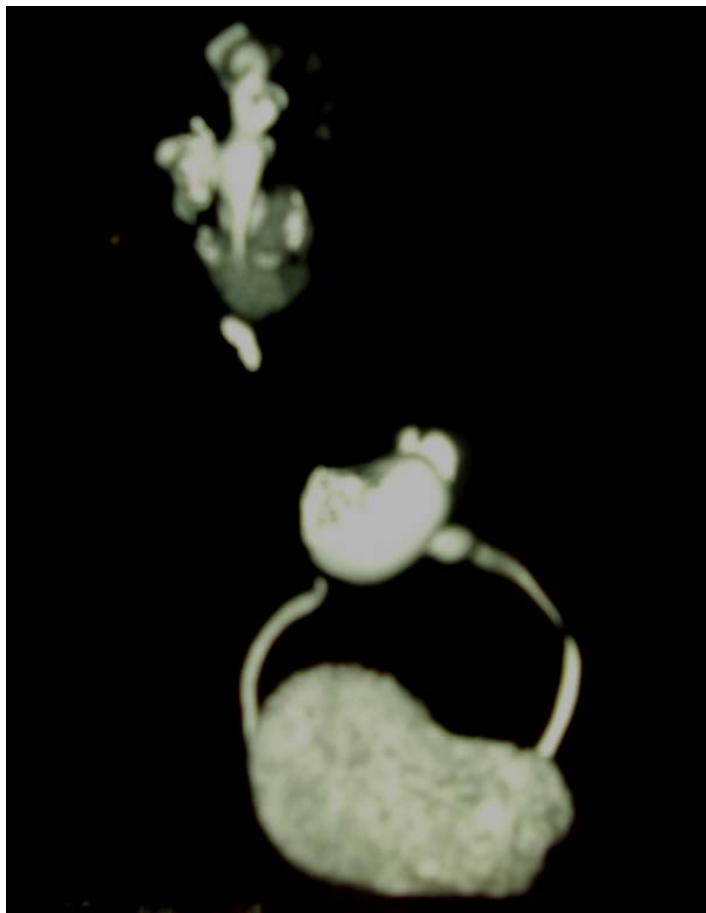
Computed tomography showed a left-to-right crossed ectopic kidney with a dilated pelvicalyceal system.
